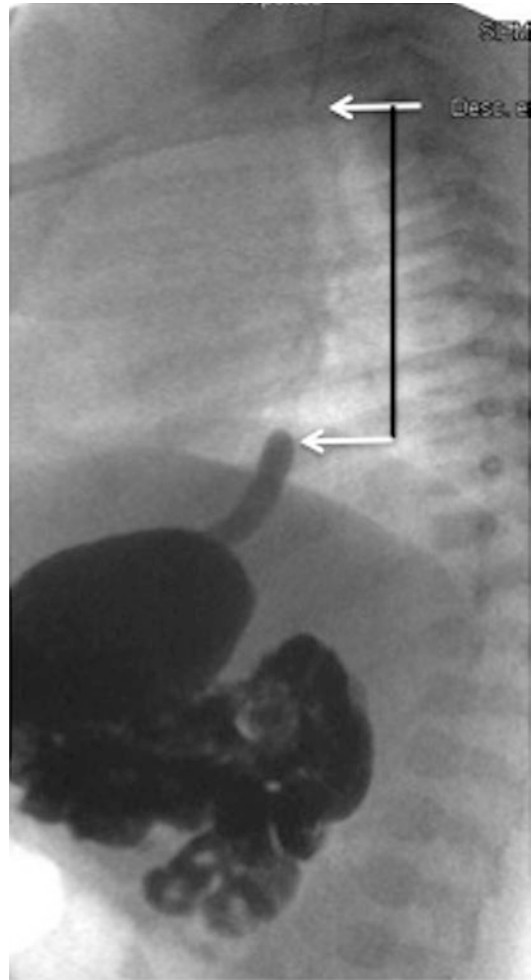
Esophageal atresia: post-natal work-up. Lateral X-ray shows the end of the proximal pouch as limited by the catheter (*upper arrow*). The distal esophagus is opacified by reflux secondary to gastric filling by a gastrostomy (*lower arrow*). The gap between the two-blind ends is measured between the arrows (*black line*)
